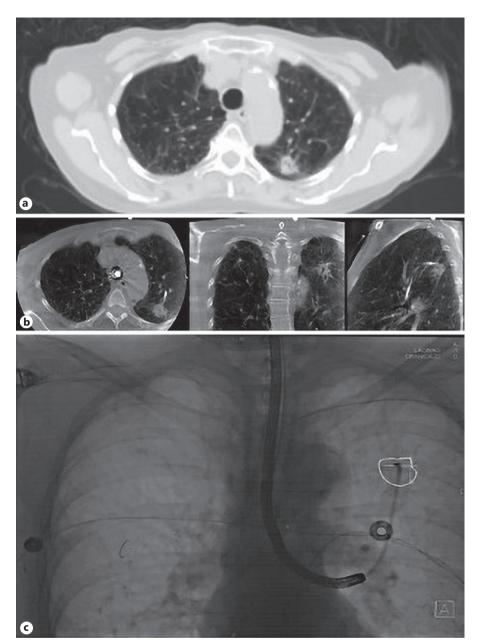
CBCT-guided bronchoscopy case. CT chest of a LUL lung nodule (a); axial, coronal, and sagittal planes showing needle in proximity with the lung nodule target (b); fluoroscopy image showing guide sheath with needle in the LUL lesion (lesion is not visible by fluoroscopy) (c). CBCT, cone-beam computed tomography; CT, computed tomography; LUL, left upper lobe.
